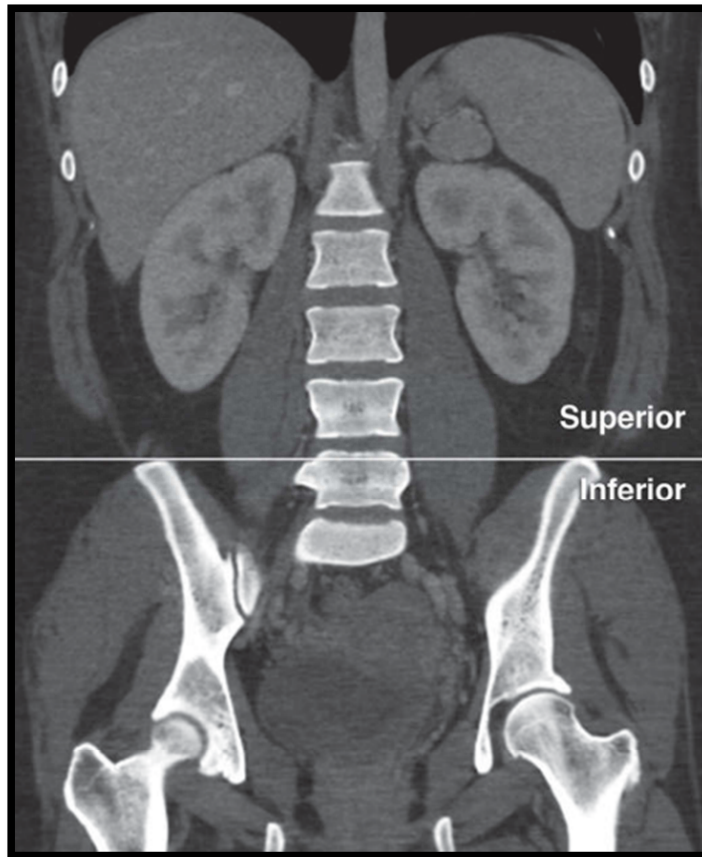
Coronal view of appendix on CT
